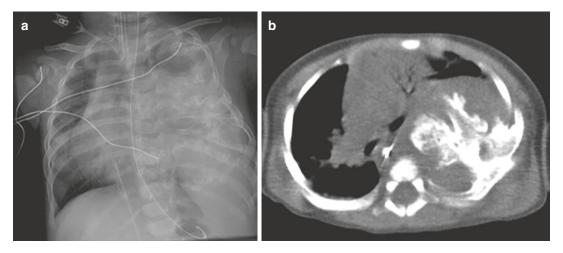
Chest wall deformity. (a) Chest radiograph in a newborn with "chest mass" seen on prenatal US shows a large dense left lung opacity with involvement of multiple left ribs. (b) Axial CT chest image shows a soft tissue mass containing ossified elements arising from multiple left-sided ribs. Pathology was consistent with mesenchymal hamartoma
